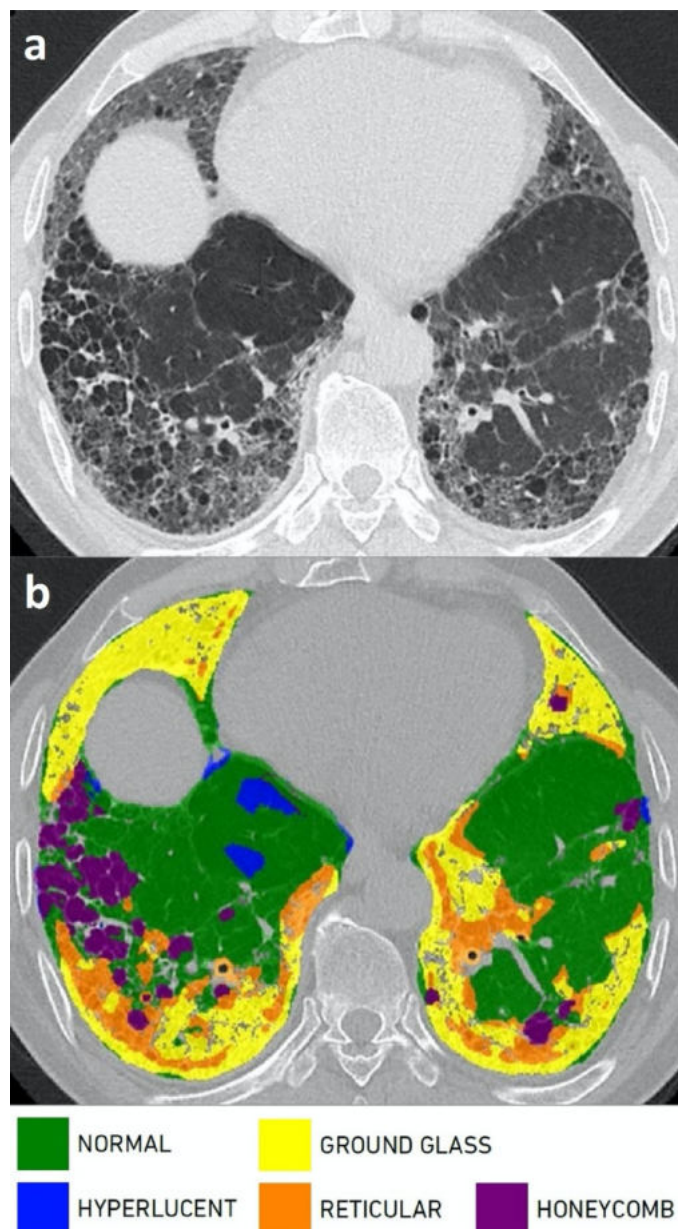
Axial CT slice (a) and its color overlay (b) representing the mapping of lung texture detection. Five different parenchymal patterns (normal parenchyma, ground glass pattern, hyperlucent parenchyma, reticular pattern, and honeycombing) were automatically detected by the computer. The computer assigned five different colors for these five different parenchymal patterns, as listed below the image (b). The lung parenchyma was then colored regionally by the computer in accordance to the dominant parenchymal pattern in that region.
